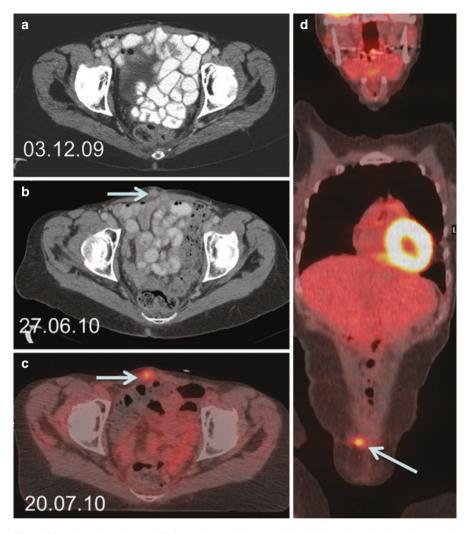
Role of FDG PET-CT in patients with unexplained rising CEA levels. 78-year-old female with colorectal carcinoma and peritoneal metastases which were treated with cytoreduction and HIPEC with a complete resection. Rising tumor markers. First follow up contrast enhanced CT (a) was unremarkable. Subsequent follow up CT at 6 months (b) failed to report a subtle anterior abdominal wall nodule (arrow). Fused PET-CT image (c and d) clearly demonstrate an enlarging FDG avid nodule (arrows). This was resected and was confirmed as an abdominal wall implantation metastasis. Patient is on follow up and remains disease free
